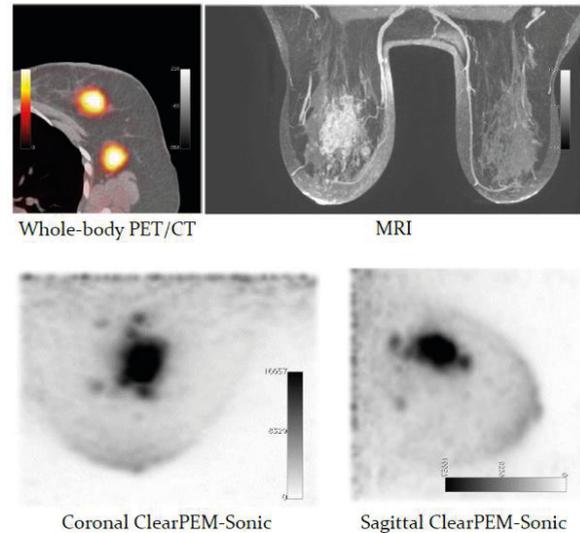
Comparison of standard Whole Body PET/CT, MRI and ClearPEM-Sonic imaging of a multifocal breast cancer.
